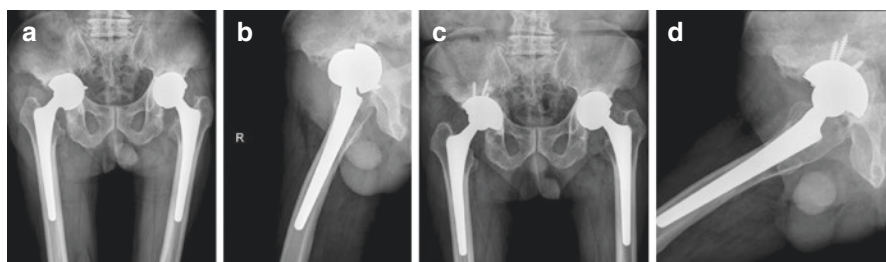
A 67-year-old man sustained intrapelvic migration of the loose metal cup 6 years after metal-on-metal THA. Radiographs showed Paprosky type IIIB acetabular defect (superior migration 3 cm, ischial lysis, and loss of Kohler line (a and b)). One year after revision with impacting grafts of the medial wall and cementless acetabular component TM (trabecular metal) cup showing osteointegration of the porous surface of the TM cup to the superior wall and ischium (c and d) (these pictures were agreed by the patient for publication)
